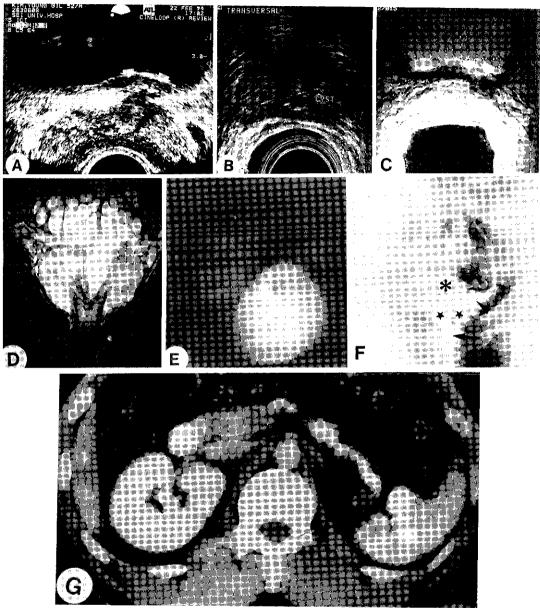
Wolffian duct anomaly associated with ejaculatory duct cyst, ectopic ureter, and unilateral renal agenesis in 52 year old patient. A. Transrectal ultrasound reveals unusually hypoechoic left ectopic ureterocele (white arrows), which continues the seminal vesicle (dark arrow). B. Another view shows hypoechoic midline cyst. C. On axial T2-weighted image, a deficted fistulous tract (dark arrow) is found from ectopic ureterocele (white arrows) to the left seminal vesicle. D. Coronal T2WI shows eccentrically located ejaculatory duct cyst and markedly dialted seminal vesicles. E. Endoscopy shows a verumontanum as an enlarged cystic structure. F. Left seminal vesiculography opacified the seminal vesicles (asterisk and stars) which connected vas deference (empty arrow), ejaculatory duct cyst (large arrow) and ectopic ureterocele (arrow head) which Joins with ureter (small arrow). G. Computed tomography at the level of the kidney demonstrates the absence of the left kidney.
